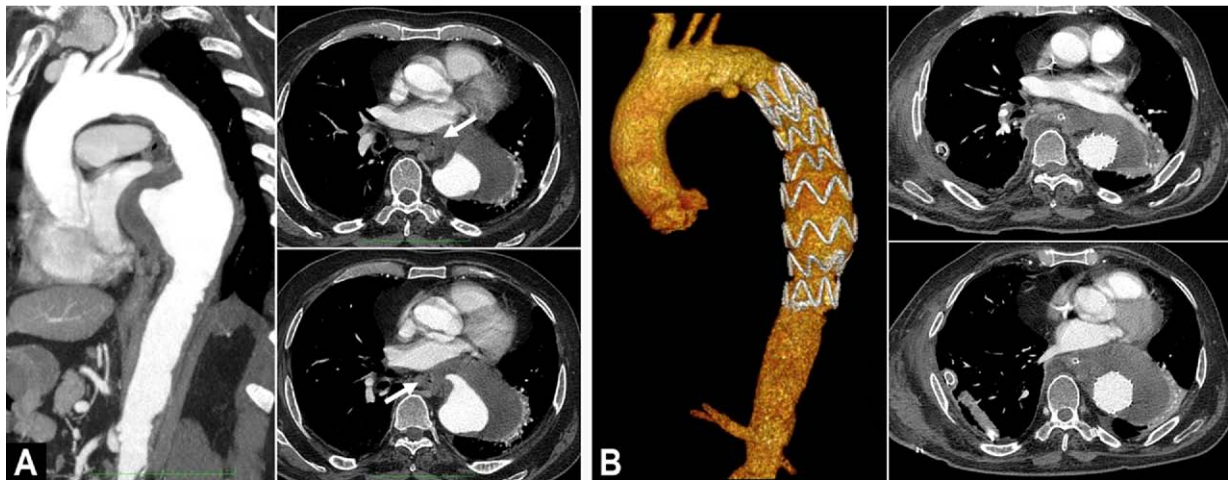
A, Preoperative computed tomography (CT) scan showing a saccular aneurysm of the descending thoracic aorta with fissured thrombus. Esophageal compression and wall thickening are evident on axial images (*arrows*). B, Postoperative CT scan after successful endovascular exclusion of the aortic aneurysm. Esophageal defect was surgically repaired via right thoracotomy 6 days after thoracic endovascular aortic repair (TEVAR).
